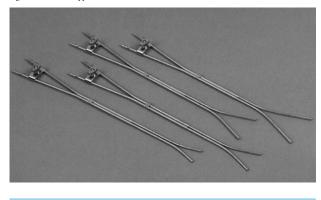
Norman Simon capsules (top right) and CT planning images of capsules in situ with CTV and isodoses
